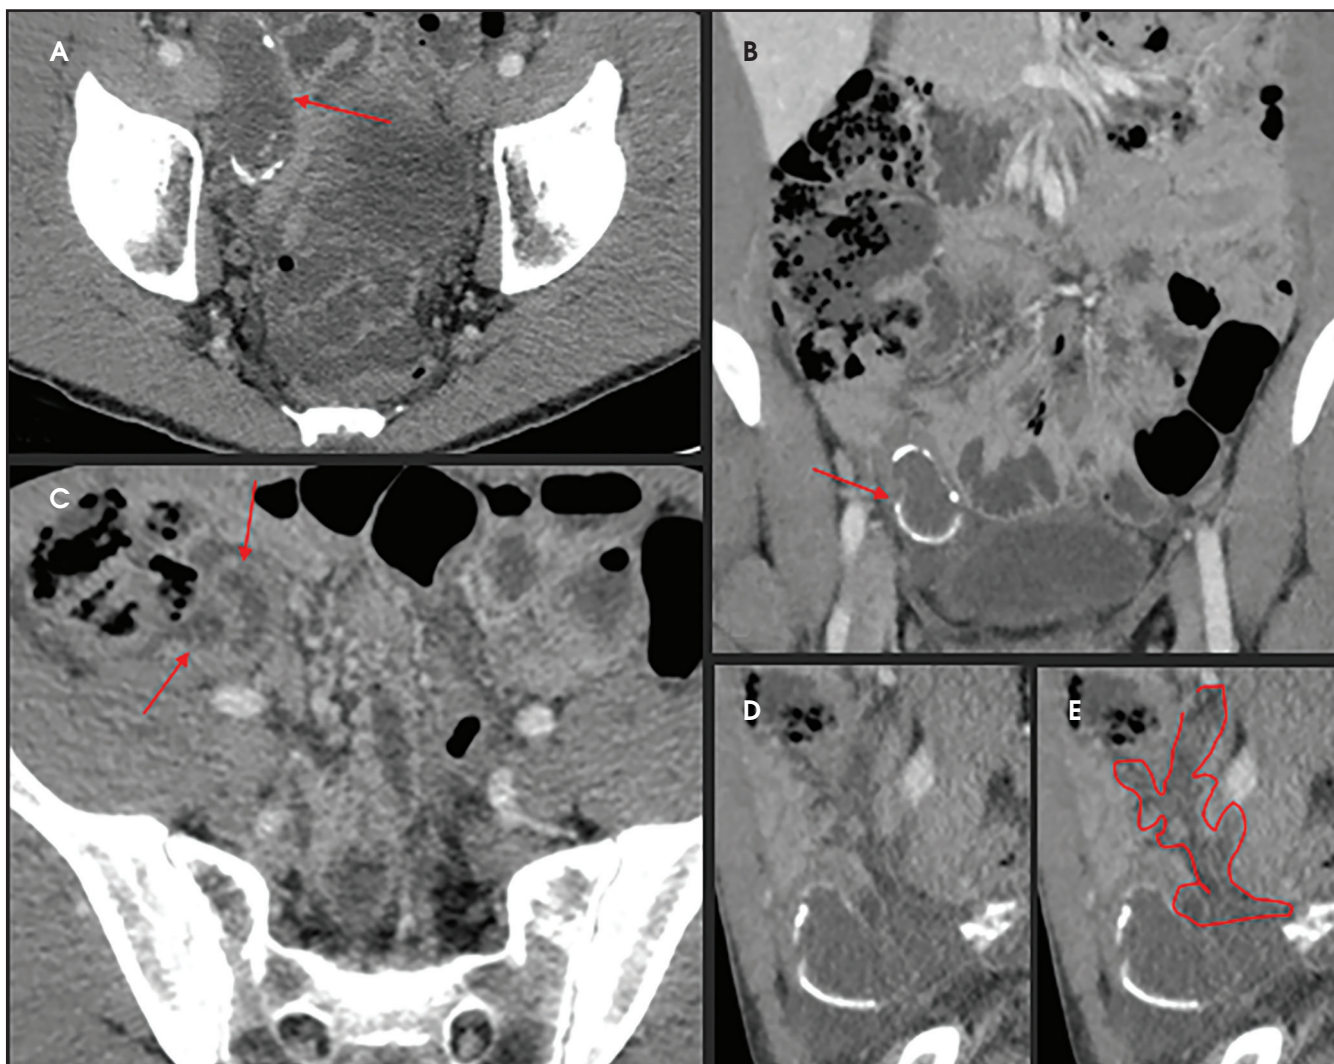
Abdominal CT with intravenous contrast (venous phase) that shows a mucocoele and an appendicular torsion. (A,B) A hypodense lesion with peripheral calcifications is observed in the abdominal RLQ. The lesion has oval morphology and appears to correspond to an appendicular mucocoele. (C) This axial image shows two hypodense structures (arrows) corresponding to the proximal portion of the appendix, which is rotated on its own axis. (D) The twisted mesoappendix is seen outlined in red. (E) The twisted mesoappendix is seen outlined in red.
